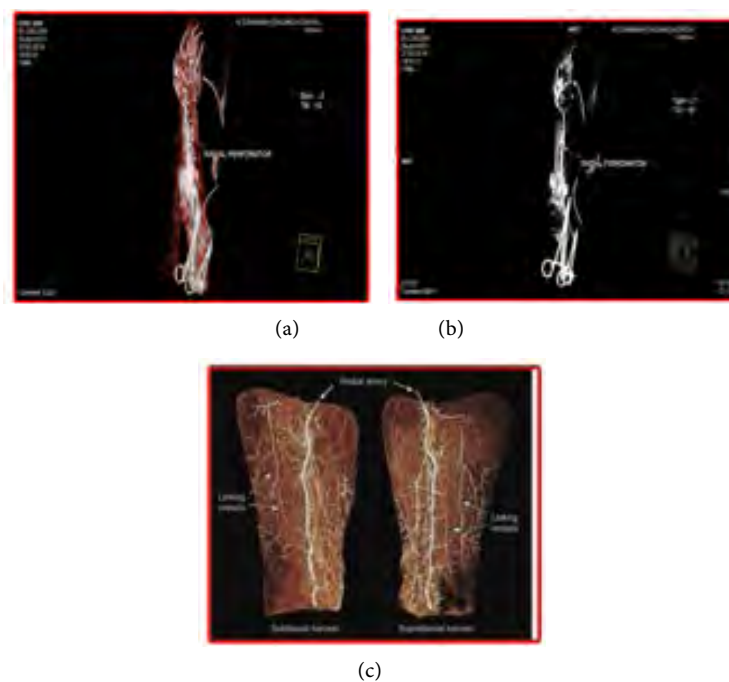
CT angiography of radial artery perforators.
